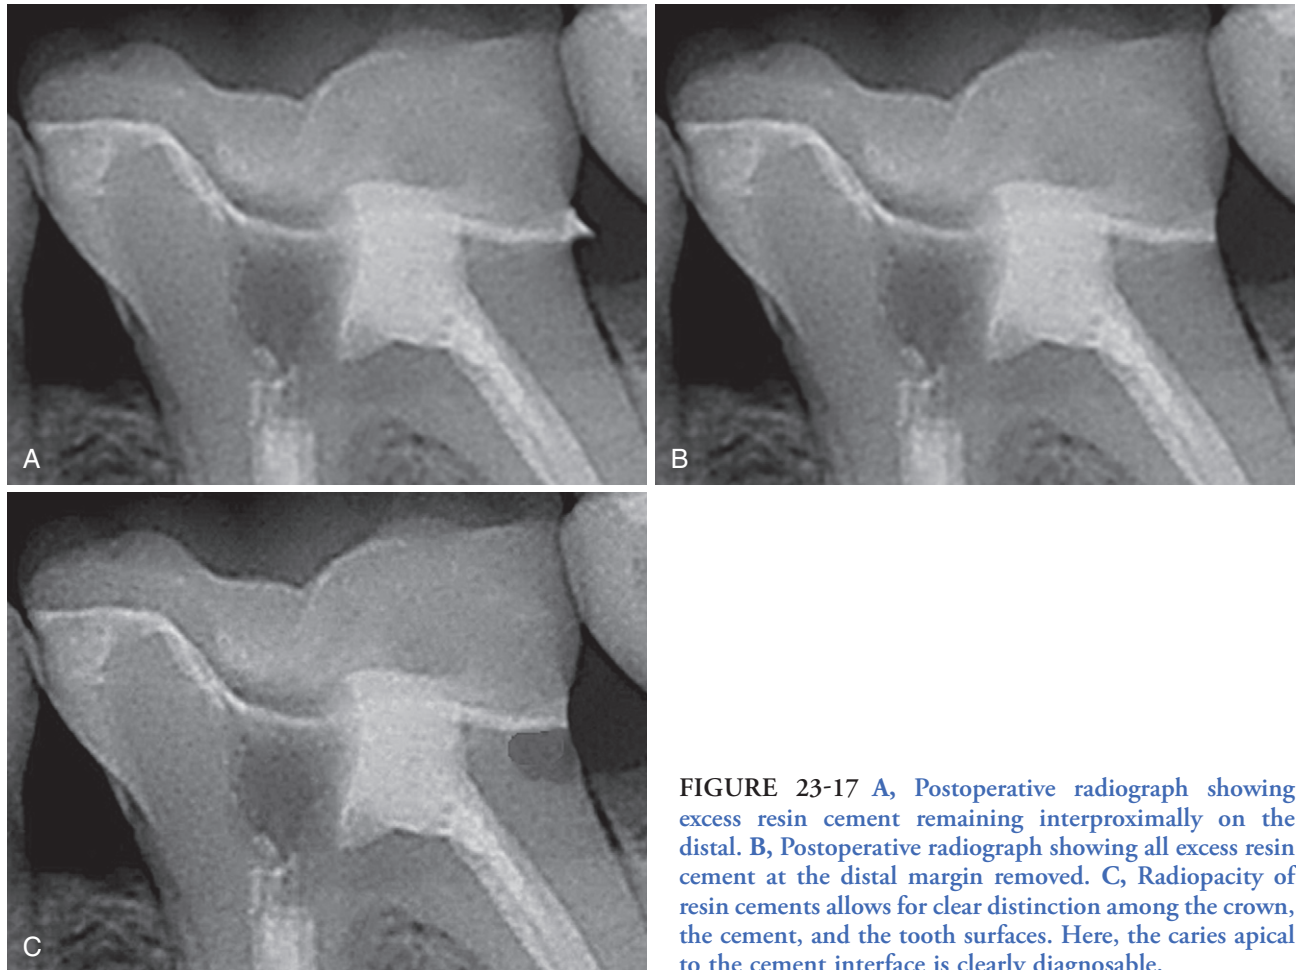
A, Postoperative radiograph showing excess resin cement remaining interproximally on the distal. B, Postoperative radiograph showing all excess resin cement at the distal margin removed. C, Radiopacity of resin cements allows for clear distinction among the crown, the cement, and the tooth surfaces. Here, the caries apical to the cement interface is clearly diagnosable.
